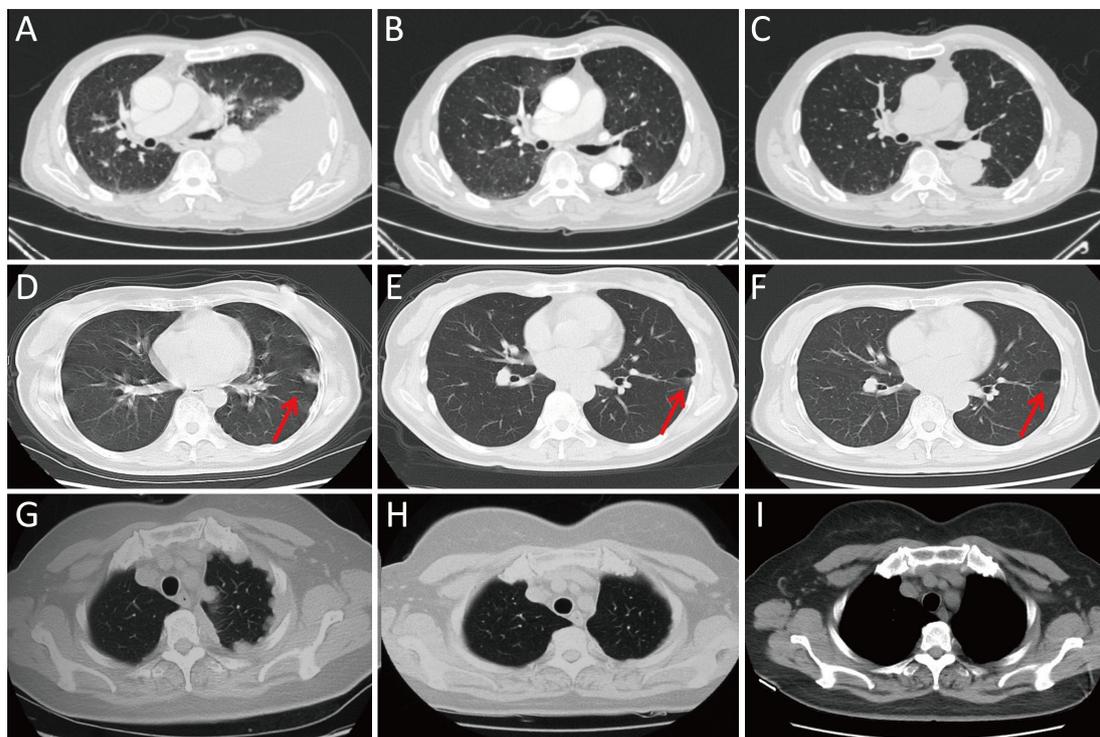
Initial computed tomography (CT) scans of the thorax and repeated CT scans after 1 month and several months of crizotinib treatment. (A, D, G) Initial CT scans from Patients 8 (A), 26 (D) and 13 (G). (D) and (G) are CT scans after malignant pleural effusion (MPE) drainage. The red arrow shows a lesion in the pleural membrane; (B, E, H) CT scans showing the efficacy of crizotinib treatment in Patients 8 (B) and 26 (E). The red arrow shows that the primary lesion became a bulla in the pleural membrane, and the pleural and lung lesions disappeared. A partial response is obtained in Patient 13 (H) in whom the pleural lesions are reduced; (C, F, I) Repeated CT scans after 7 months of crizotinib treatment in Patient 8 (C), after 5 months in Patient 26 (F), and after 12 months in Patient 13 (I).
